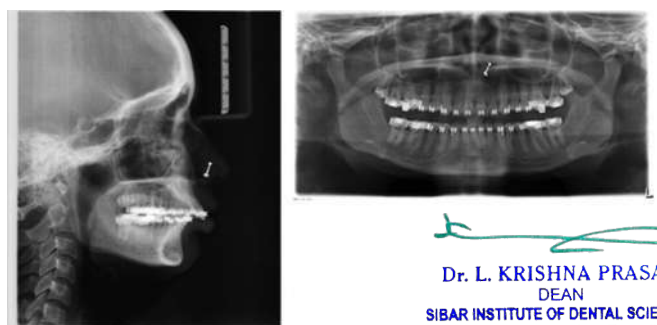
Presurgical radiographs of case report 1
